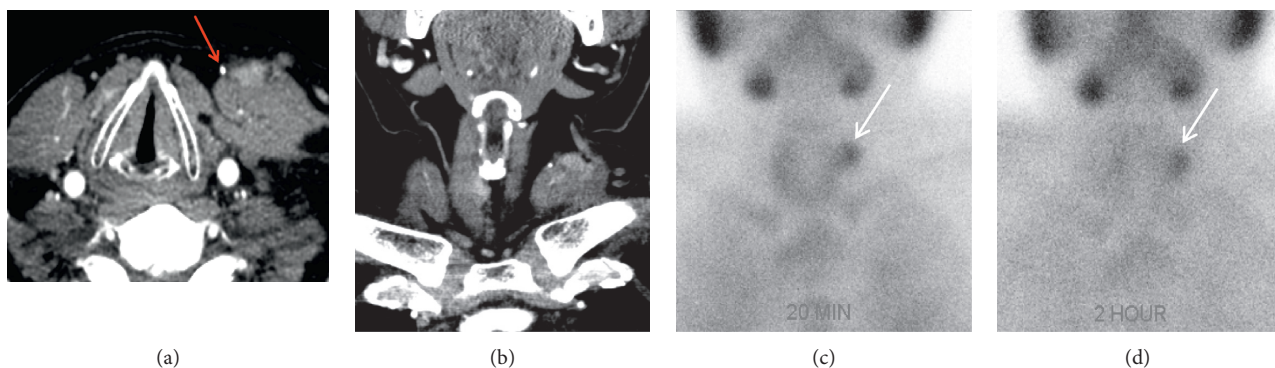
Hyperfunctioning autotransplanted parathyroid remnant. A 50-year-old male with multiple endocrine neoplasia type 1 (MEN1) presents with recurrent disease after prior parathyroidectomy. Axial (a) and coronal (b) four-dimensional computed tomography (4DCT) images show an irregular enhancing focus (white arrows) superficial to the left SCM muscle, lateral to a surgical clip (red arrow). Planar immediate (c) (20 minutes) and delayed (d) (two hours) single-photon emission computed tomography (SPECT) images demonstrate focal radiotracer accumulation (white arrows) in the left lateral neck that persists on delayed images and confirms the diagnosis of the hyperfunctioning parathyroid gland.
